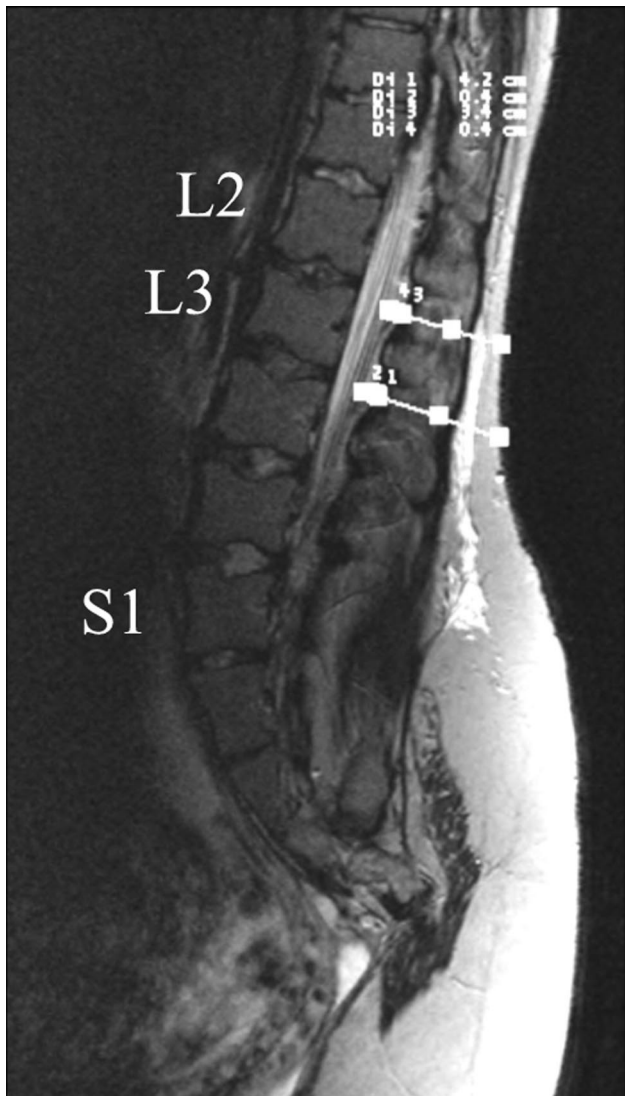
T2-weighted sagittal magnetic resonance image of lumbar spine at 35 weeks' gestation. Annotations 3 and 4 at the L2–L3 level mark the distances from skin to epidural space (3.4 cm) and epidural to spinal nerves (0.4 cm), respectively.
